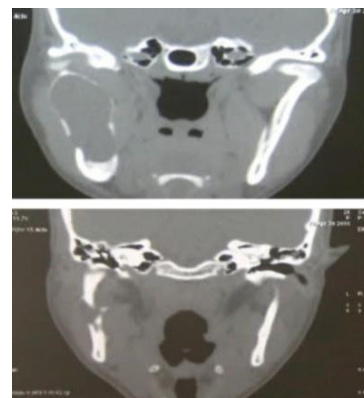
Coronal CT sections
